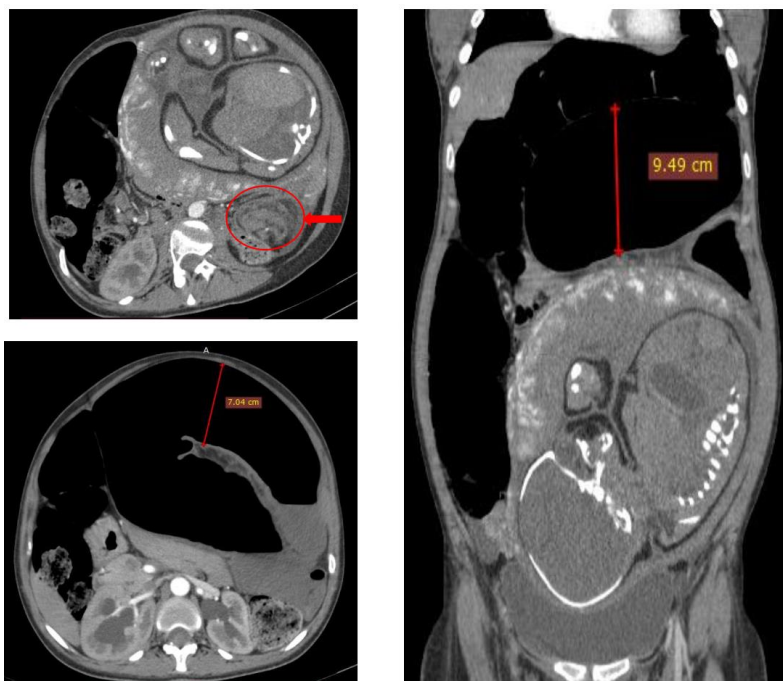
Computed tomography image of abdomen showing bowel obstruction with transition point at the level of the sigmoid colon and “whirl sign” (arrow)
